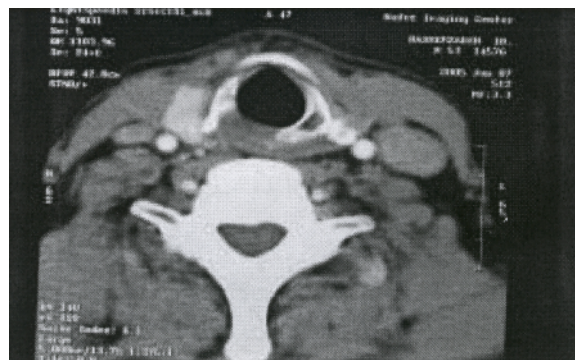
Postoperative CT scanning
